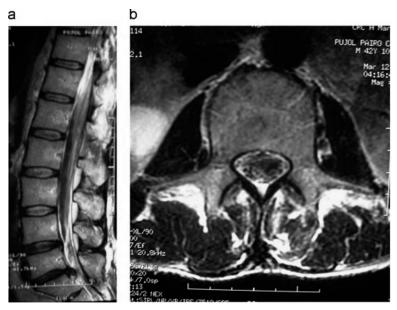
Sagittal and axial T2-weighted images showing invasion of the anterior intradural space by a hypointense T2-weighted image with slight secondary intrathecal deformity of the nerve roots.
